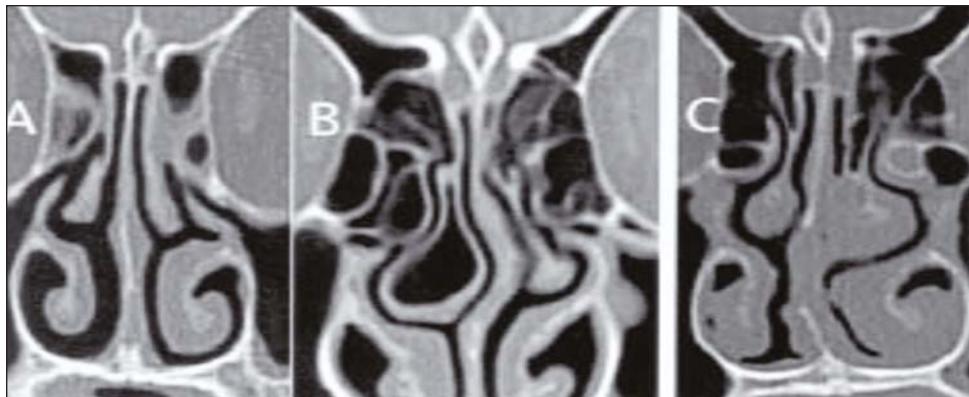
Coronal sinus CT scan with olfactory fossa A) Type I, B) Type II and C) Type III
